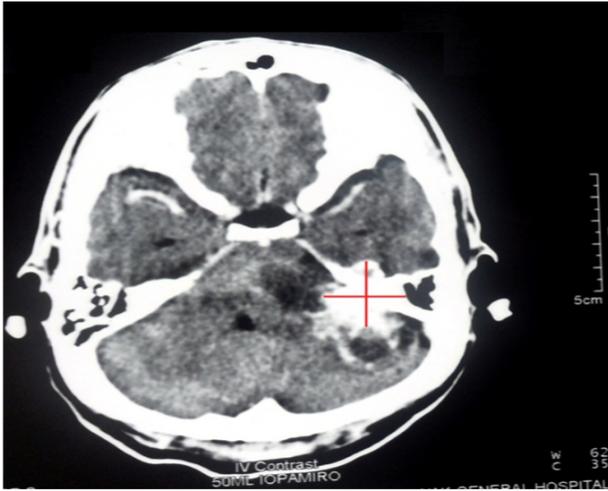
Axial cut of post contrasted computed tomography scan (CT scan) shows a mass at left Cerebello-Pontine (CP) angle with heterogenous enhancement of the solid component and enhancement of the wall of the cystic component.
